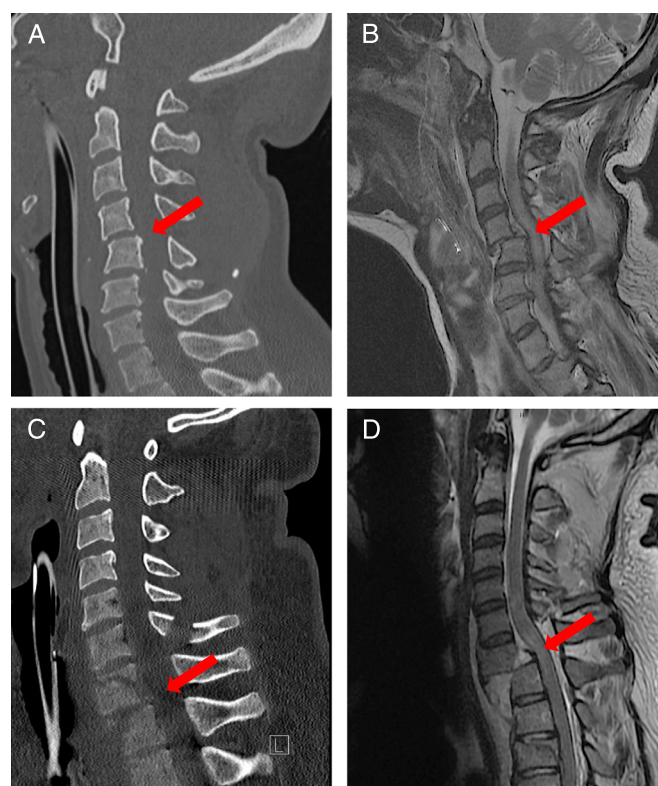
Representative images showing the risks of an MRI for patients with an unstable ATCSCI. (A) and (B) are sagittal CT and MRI images, respectively, of the same patient taken 6 hours apart, the MRI after the CT. (C) and (D) are sagittal CT and MRI images, respectively, of the same patient taken 2 hours apart, the MRI after the CT. In both patients, the ATCSCI evolved into cord compression between the two scans.
